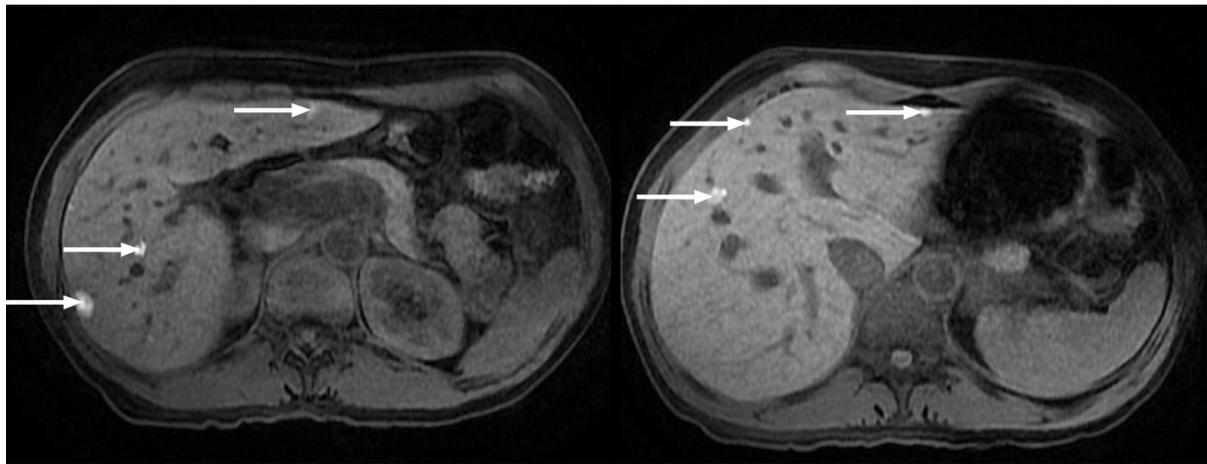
Multiple liver metastases from melanoma. Hepatic metastases showing a characteristic high signal on fat saturated T1-weighted imaging due to their melanocytic content (arrows).
